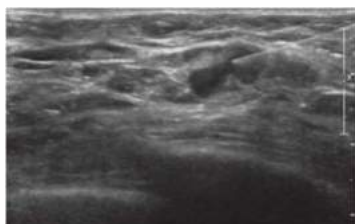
• Ultrasound-guided fine needle aspiration of an axillary lymph node that revealed metastatic carcinoma in a male breast cancer patient who underwent an MRM.
